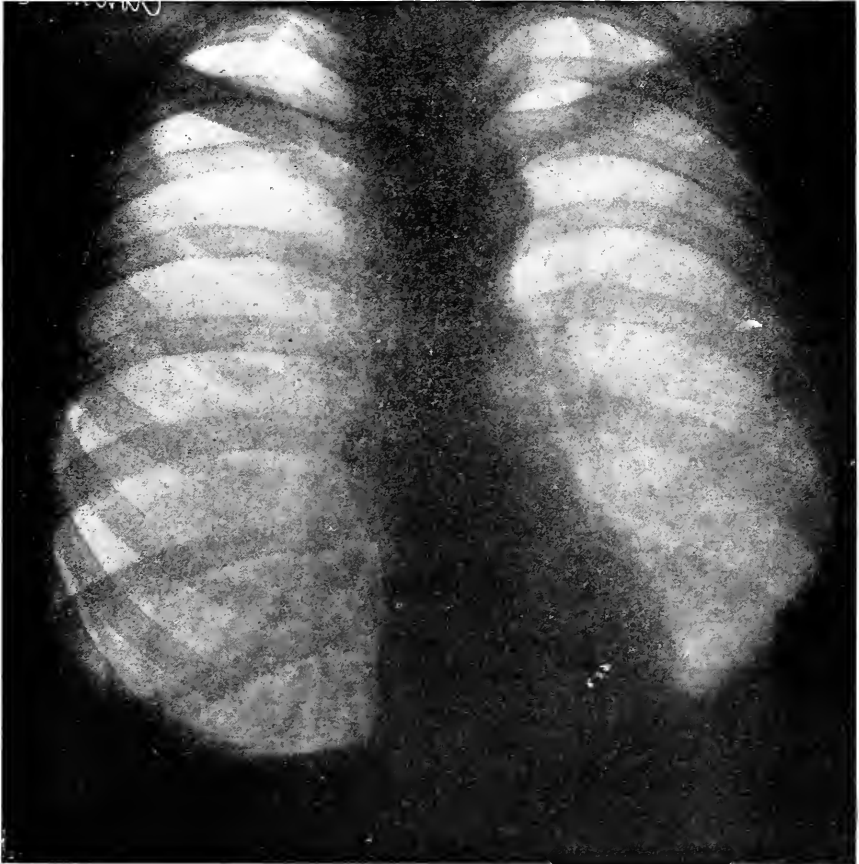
Spontaneous pneumothorax on right side. Adhesion of lung to lower and lateral aspect of chest wall has prevented complete collapse of lung. (Roentgenogram by Dr. H. K. Pancoast.)
